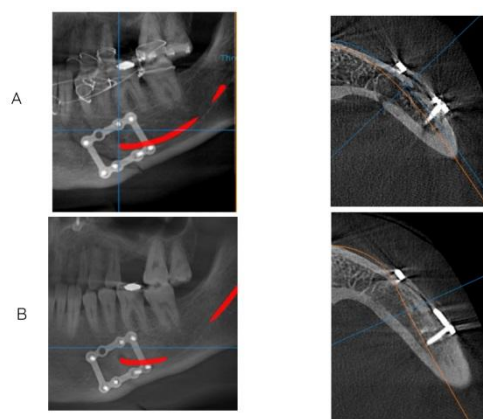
A. Immediate postoperative CBCT scan, B. CBCT after 3 months
